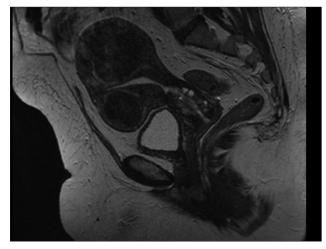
Pelvic magnetic resonance imaging – Sagittal view – Two nodules in the uterine wall suggestive of leiomyomas, thickening of the junction zone due to probable adenomyosis, and an agglomerate of cystic formations at the uterine cervix
